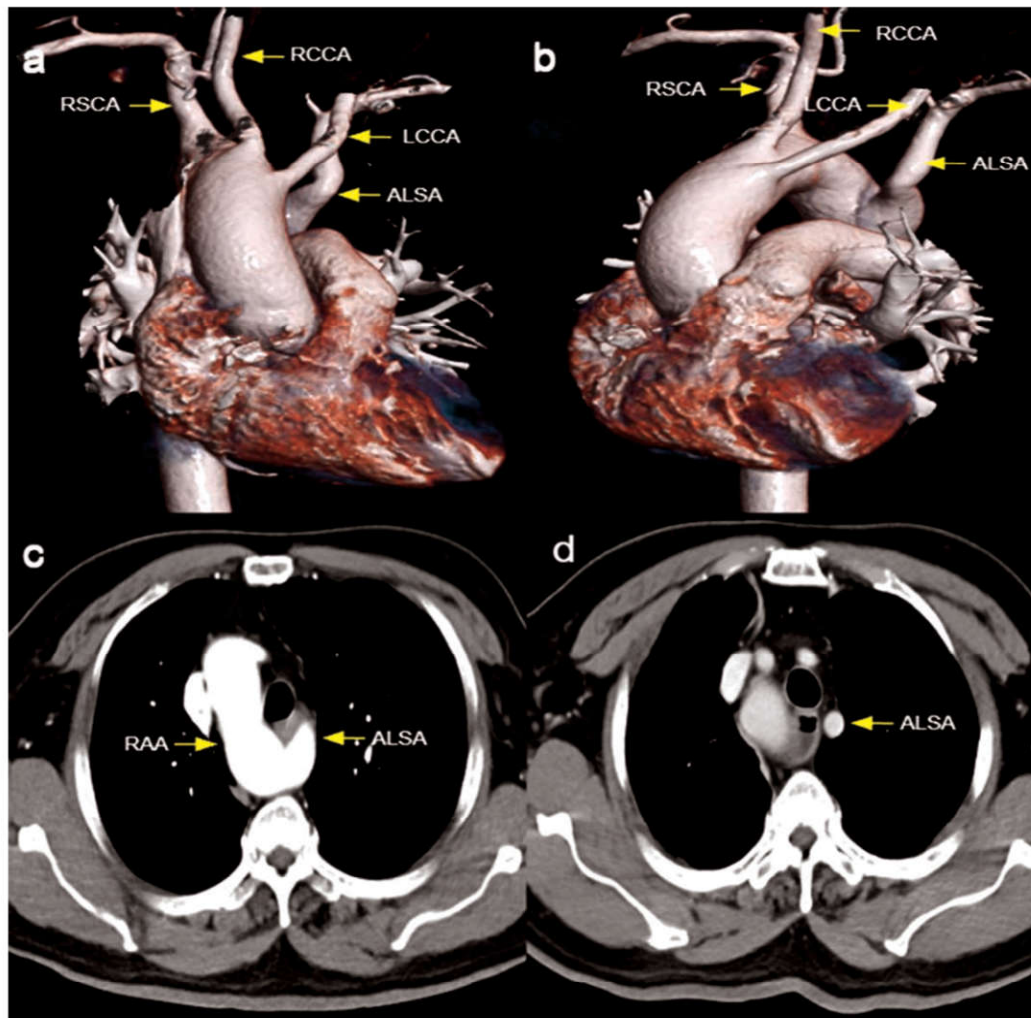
Axial CT chest contrast and VRT images showing right sided aortic arch with aberrant left subclavian artery.
